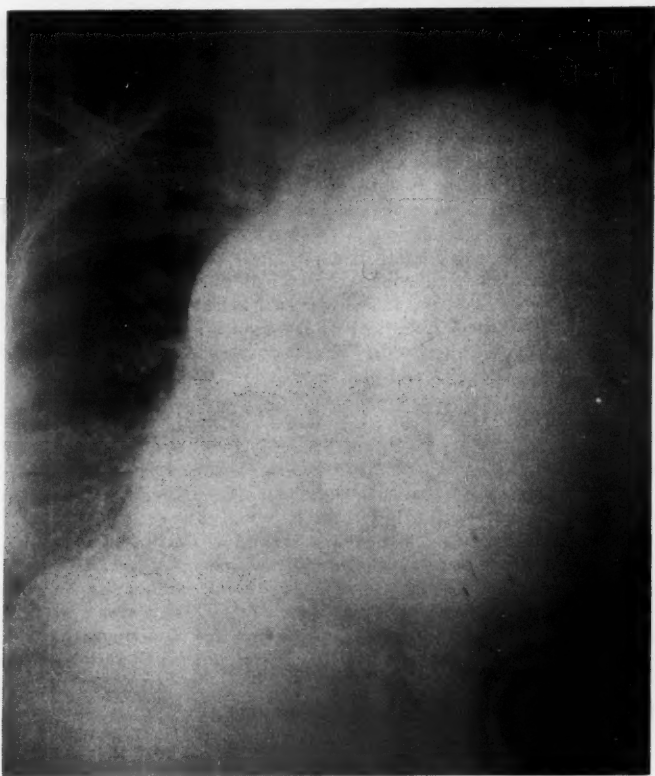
Preoperative anteroposterior roentgenogram revealing the left hemithorax completely obscured by the tumor. The calcification is not well demonstrated but could be visualized on the original film.
